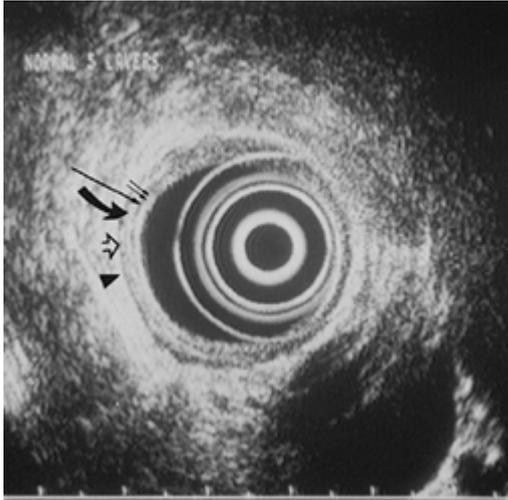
Endoscopic ultrasound image of the normal five-layered esophagus. Two small arrows: The inner-most layer corresponds to an interface echo and the mucosa. Single long arrow: The second layer corresponds to the mucosa (including the muscularis mucosa). Curved solid arrow: The third layer corresponds to the submucosa. Open arrow: The fourth layer corresponds to the muscularis propria. Solid arrowhead: The fifth outer-most layer corresponds to an interface echo and the adventitia (serosa equivalent). The five-layered appearance is essentially the same throughout the gastrointestinal tract. Because the esophagus lacks a serosa, the fifth echogenic layer in the esophagus represents the interface echo with the adventitia.
